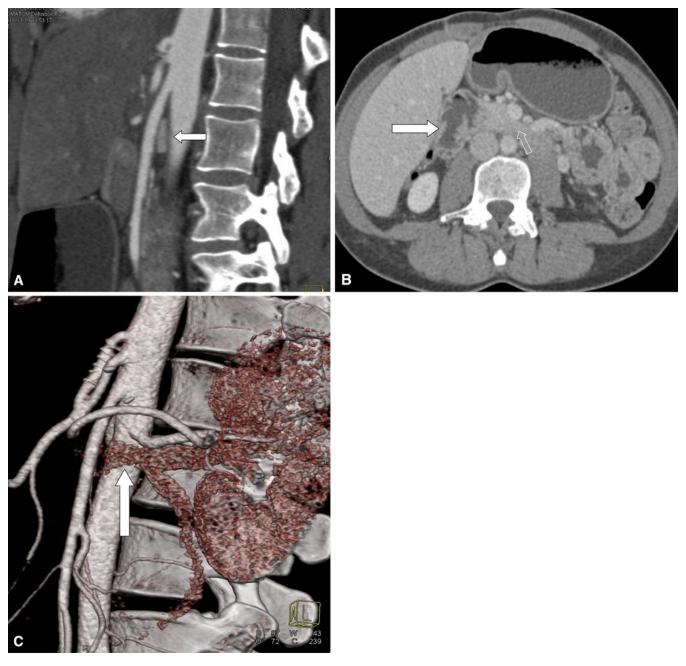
A 35-year-old female who presented with gradually increasing episodes of nausea, vomiting, and abdominal pain over the course of 6 years, with multiple visits to different emergency rooms. Her symptoms were initially attributed to her gallbladder, but her symptoms did not improve after a cholecystectomy. Sagittal CT image (A) demonstrates a
